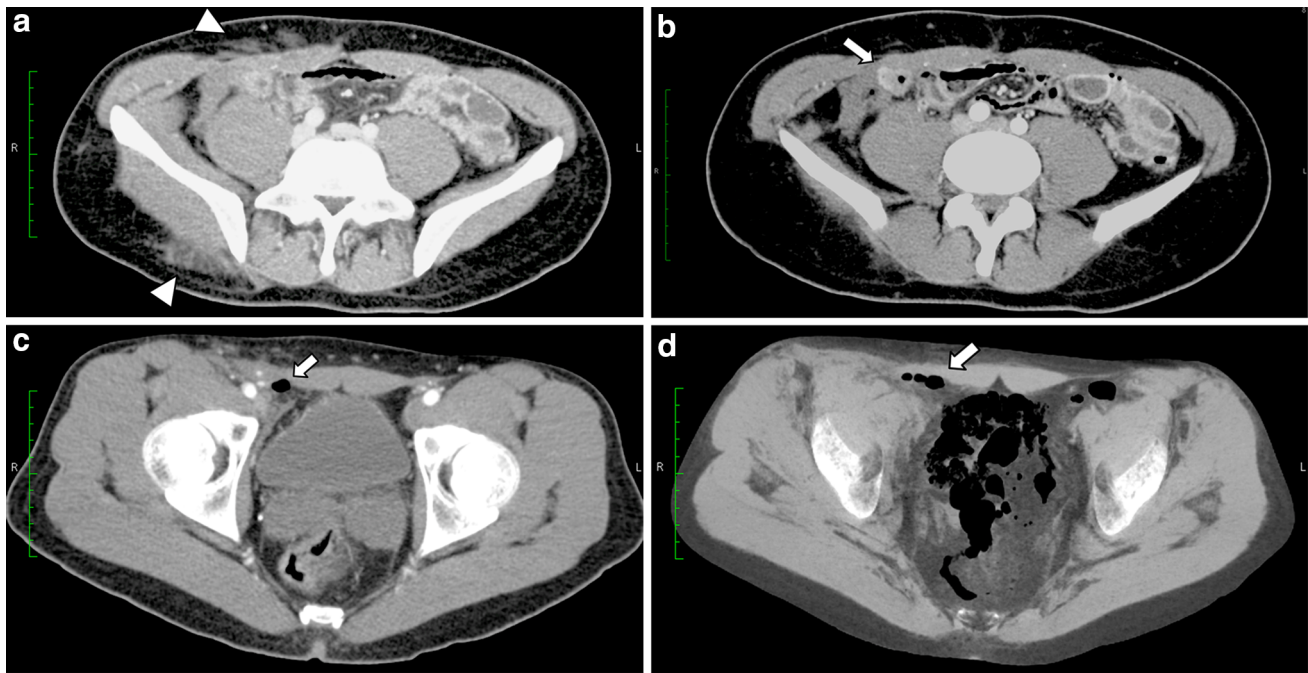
CT exams of a young motorcyclist run over by a vehicle. a Post-traumatic soft-tissue changes of the right inferior abdominal quadrant and of the gluteal region (*arrowheads*). b At the same level, a tract of terminal ileum shows abnormally increased mural enhancement and parietal thickening (*arrow*), suggestive for meta-traumatic
